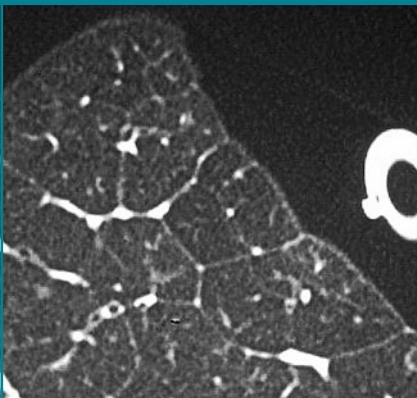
CT scan of resected lung shows lobules.
